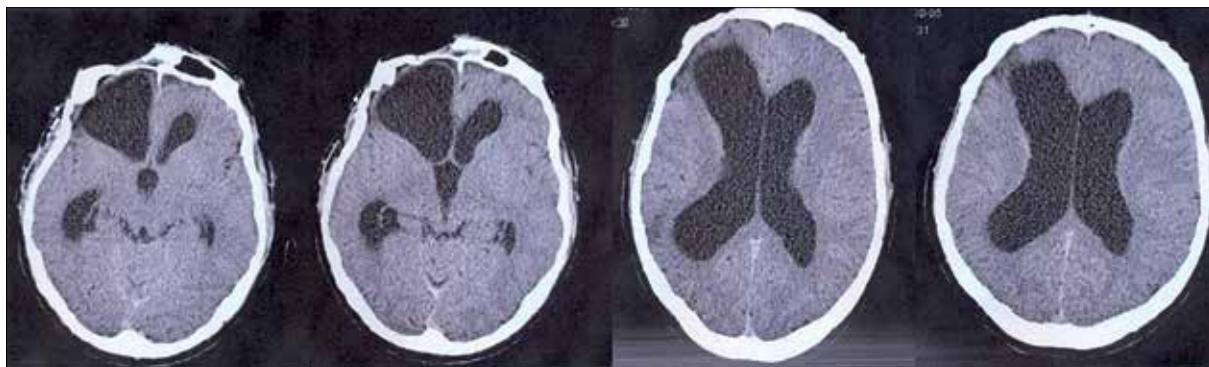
Images from a follow-up CT scan, performed one year later. Dilatation of the ventricles and extension of the right frontal cornu, caused by encephalomalacia of the right frontal lobe.
